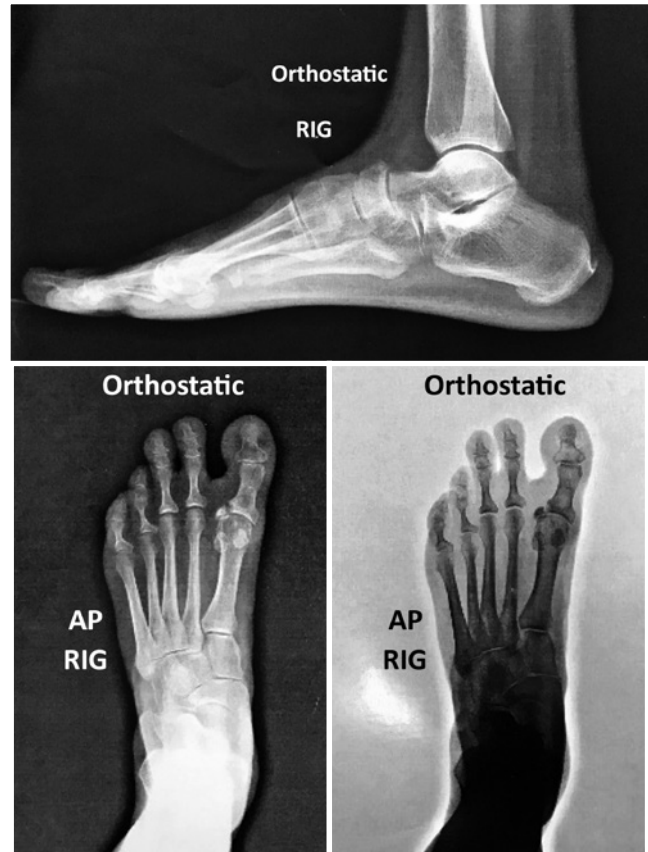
Anteroposterior and profile radiographs.
